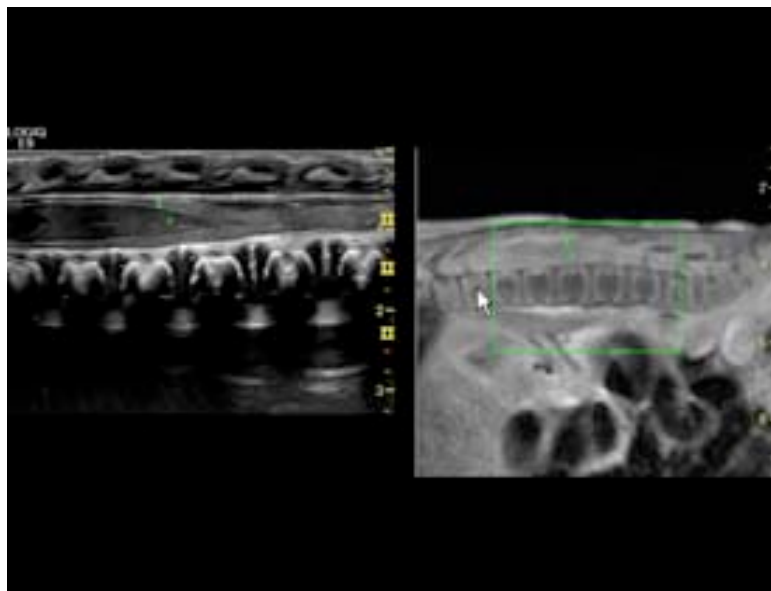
Side-by-side fusion imaging of real-time high-frequency ultrasound and MR images of a neonatal spine. Adapted from Bonner, J. (2009). Retrieved 12th February, 2012, from <http://www.diagnosticimaging.com/display/article/113619/1386317?CID=rss>
